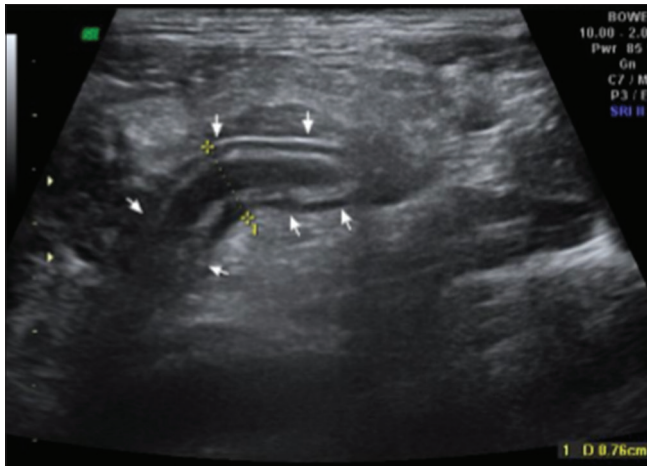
High-frequency (7.5–10 MHz linear transducer) ultrasonographic appearance in right iliac fossa in a patient diagnosed clinically as acute appendicitis showing a blind-ended, tubular, hypoechoic, aperistaltic, noncompressible structure originating from cecum having gut signature with a diameter of 7.6 mm with surrounding fat stranding and no associated lymphadenopathy
